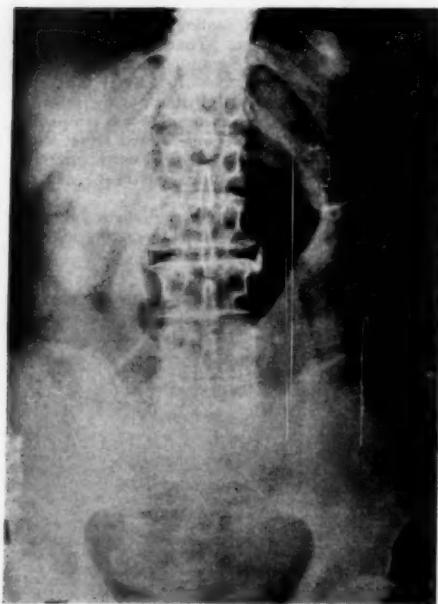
Case 1: Plain radiograph of the abdomen taken with the patient lying supine showing the distention of the bowel forming the volvulus.
